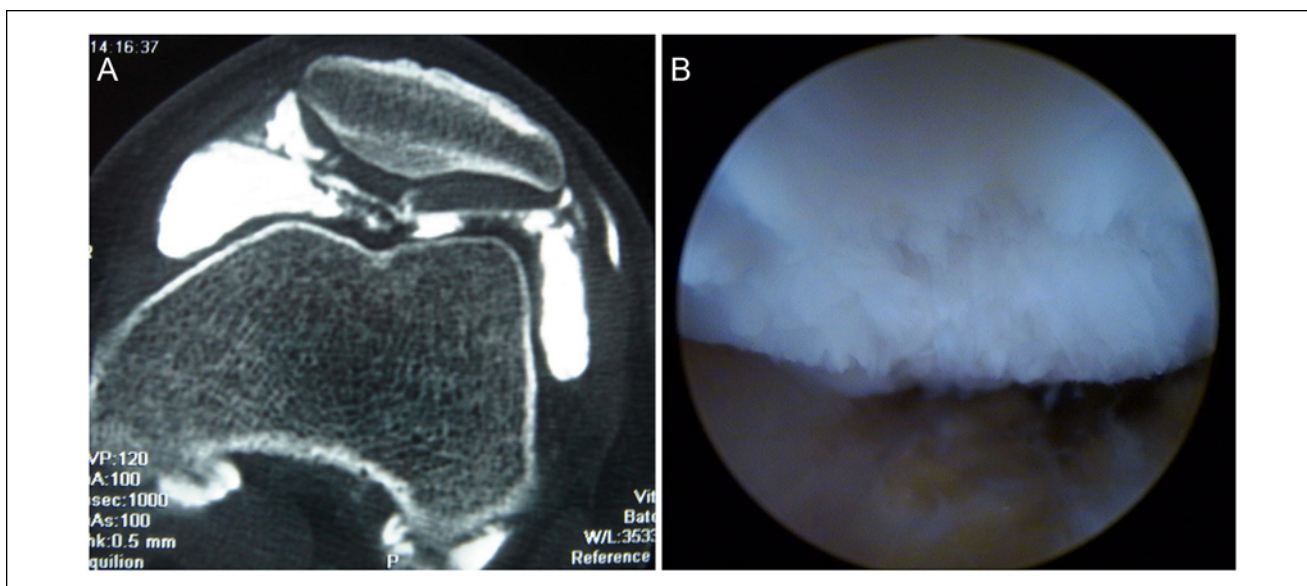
(A) Computed tomography arthrogram demonstrating central and medial patella chondral damage with loose cartilage in the patellofemoral joint. (B) Arthroscopic view in the same patient demonstrating chondral injury to the central and medial patella with loss of the patella ridge.
